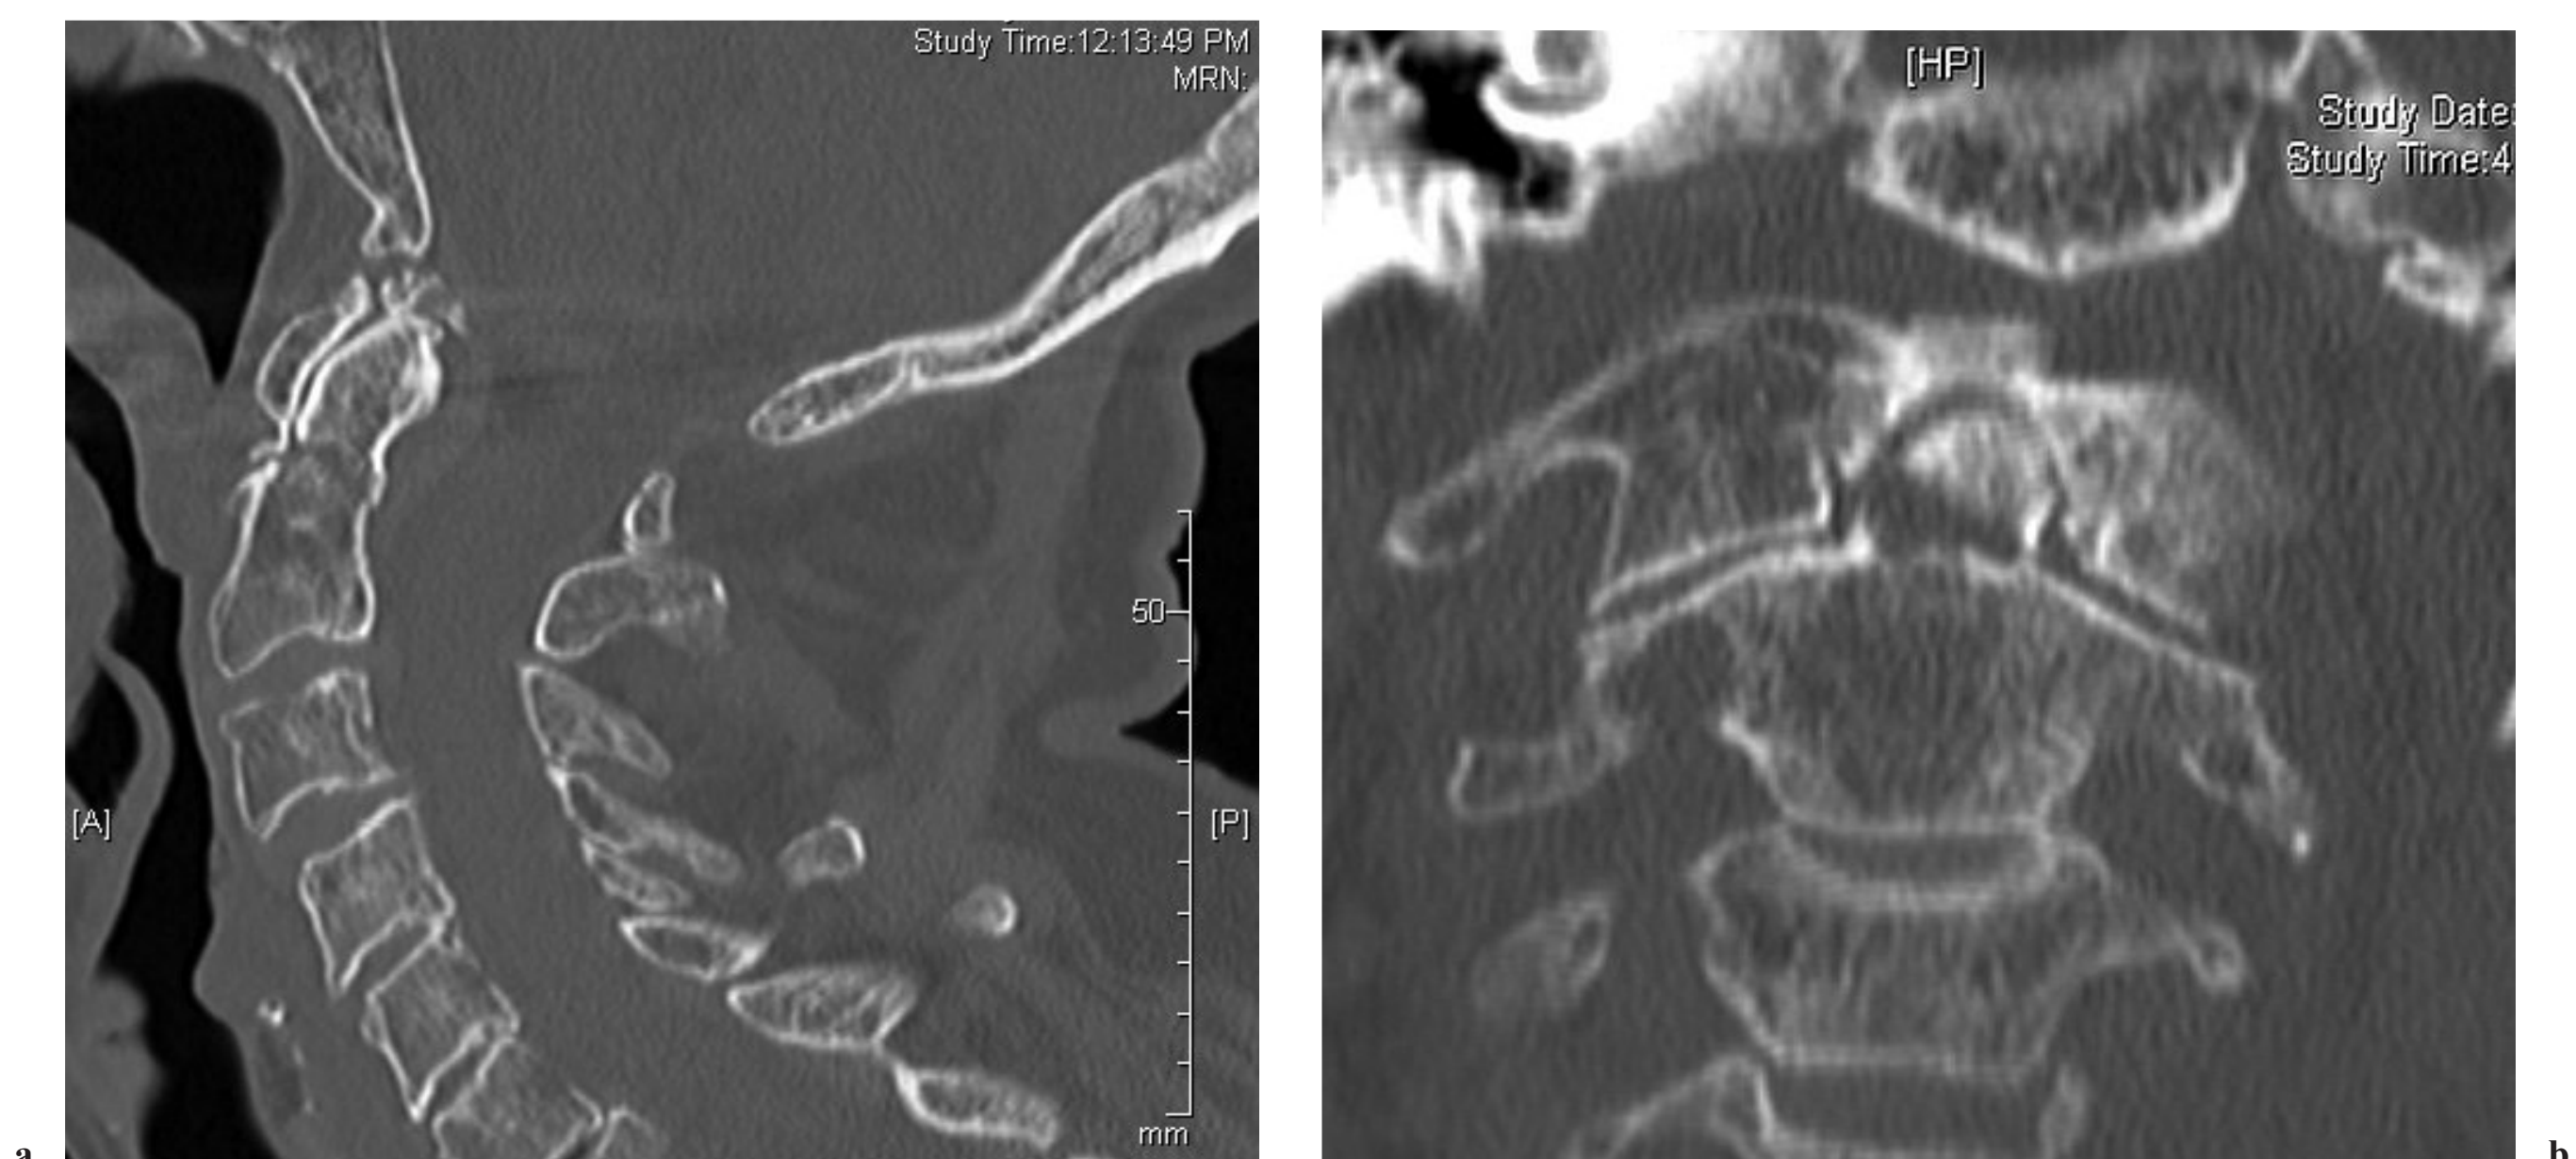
b (a) Sagittal and (b) coronal preoperative CT images demonstrating a type II odontoid fracture.
